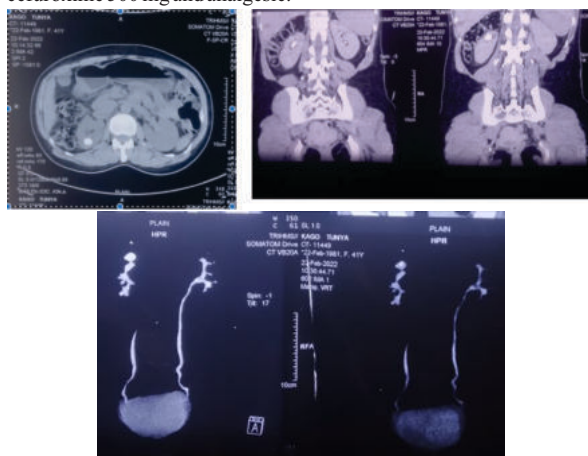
Pre PCNL CT images; a, b, c Shows Right upper calyx diverticular stone
